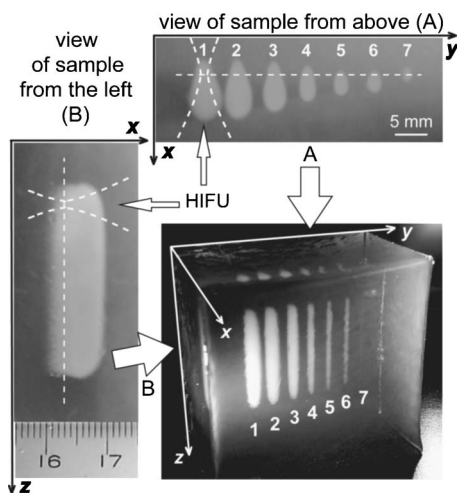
Lesion stripes formed in degassed gel sample by moving the HIFU transducer upwards with constant velocity (0.5 mm/s), constant time-average acoustic power of the transducer (15 W), and different duty cycle (and peak power) from 6.25% (240 W peak power, 1) to 8.35% (2), 12.5% (3), 25% (4), 50% (5), 67% (6), and 100% (15 W peak power, 7). Ultrasound was applied from the front of the sample as indicated by HIFU arrows. The location of HIFU focal peak is shown by the straight dashed lines, and the general shape of the HIFU beam is shown by the curved dashed lines on the views of the sample from above (A) and from the left (B). Although the average power was held constant for each stripe, the stripes have very different sizes. The highest amplitude, shortest duty cycle pulses created the largest lesion stripe (1).
